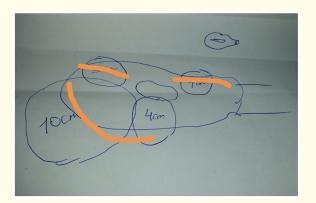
Show planning the Ultrasonographic mapping location of pre-surgical fibroids.
